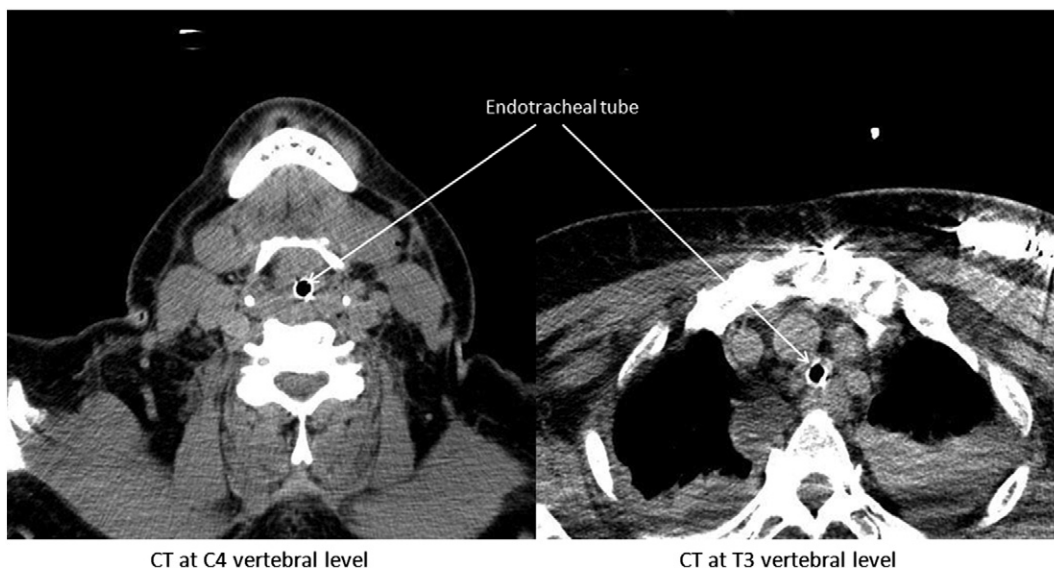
Figure Computed tomography scan of the neck performed immediately after occurrence of angioedema.
